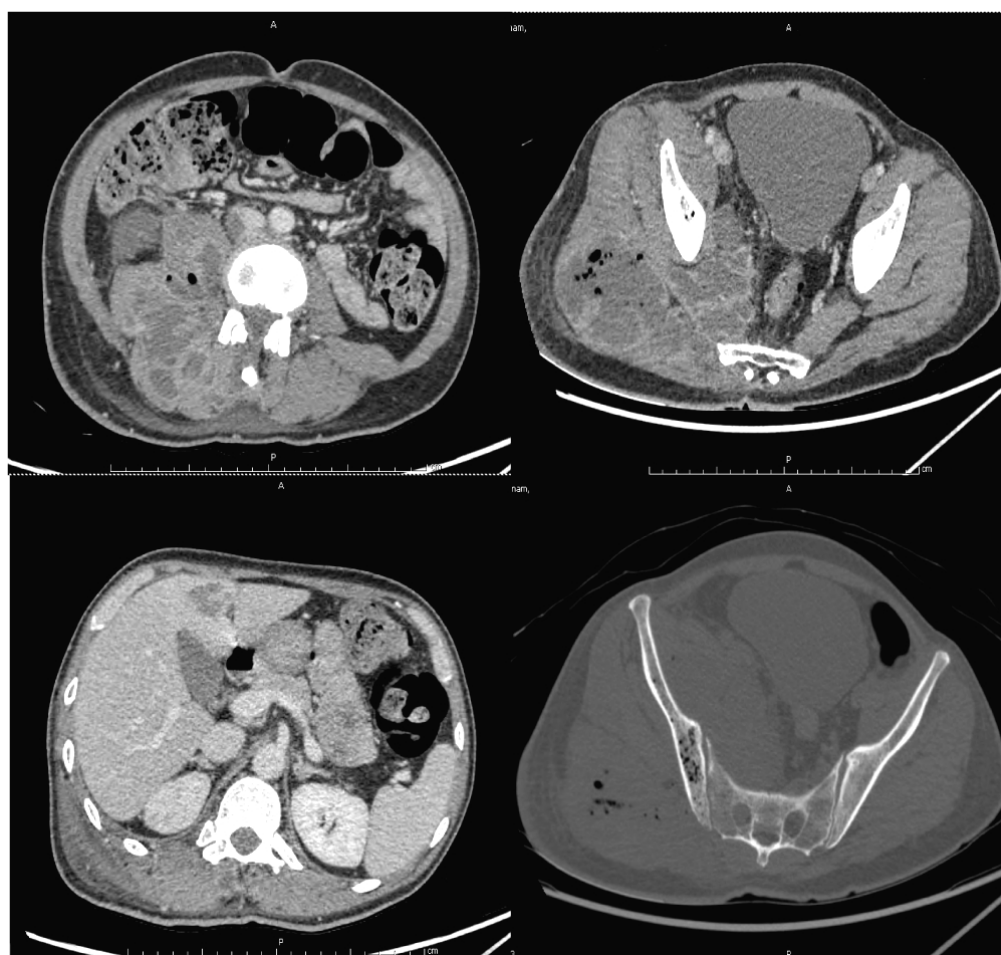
CT scan demonstrating a huge gas-forming abscess along the right iliopsoas, erector spinae, and right iliacus muscle (left, upper); another large abscess at the right gluteus maximus muscle (right, upper); and a liver abscess at segment 4b (left, lower). Osteomyelitis due to a gas-forming organism at the right iliac bone is also seen (right lower).
